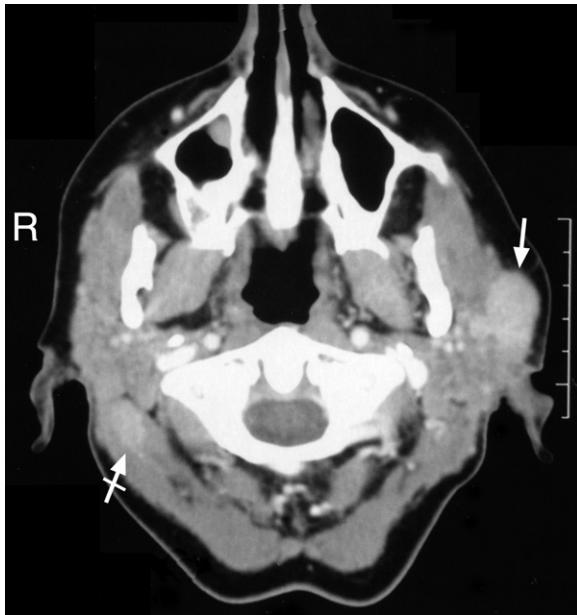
CT axial image showing (i) a mass on the left parotid gland (arrow), and (ii) involvement of some lymph nodes in the right upper neck (tailed arrow).
